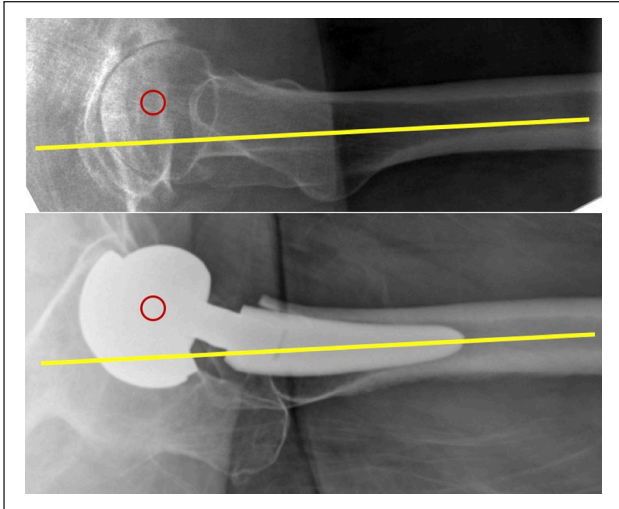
Radiographs demonstrating that the Preserve stem replicates the natural anteroposterior offset of the femoral head.
